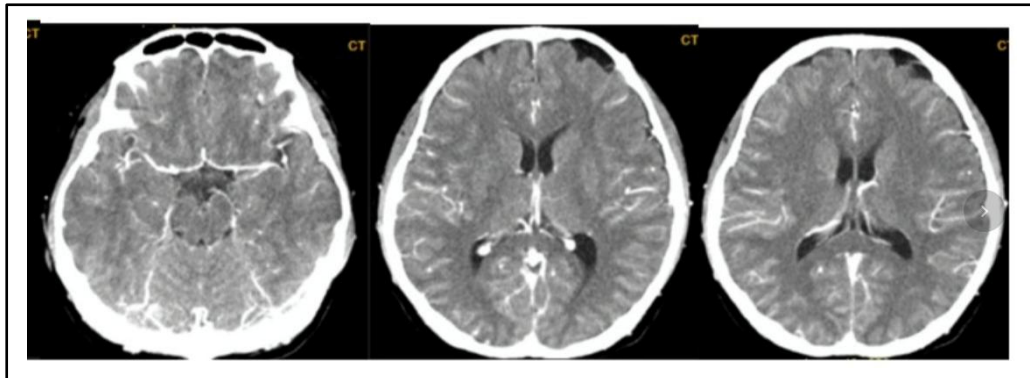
Contrast-enhanced head CT scan
